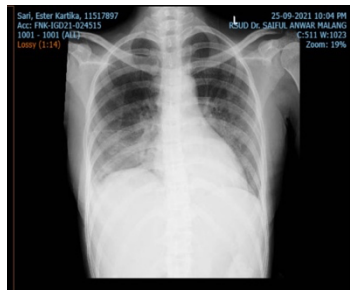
Chest X-ray image. Infiltrates were found in both lung fields.
